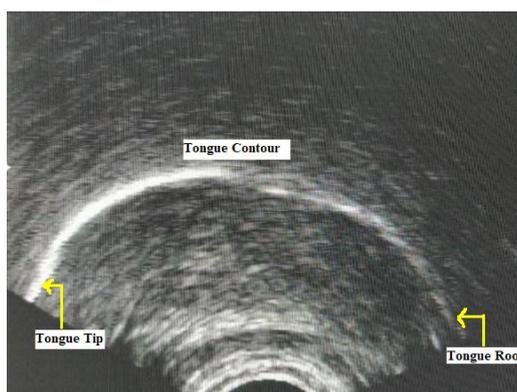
Ultrasound Image taken for the tongue in rest position
